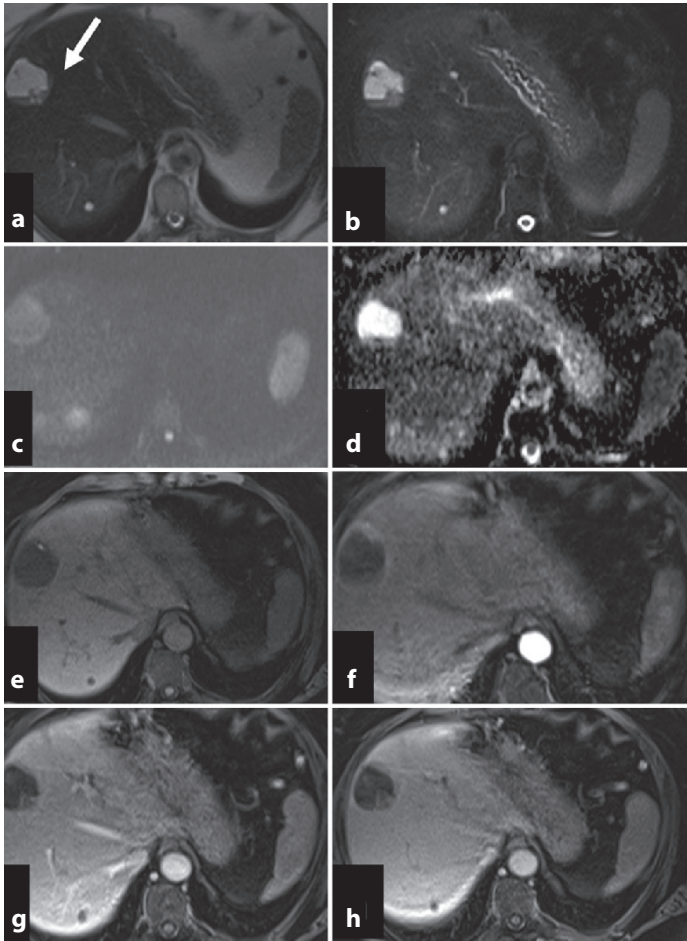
MR imaging of liver metastasis from a malignant non-functioning P-NET in a 70-year-old woman. A rounded well-defined hepatic lesion in segment VIII (30 mm) appears hyperintense on axial T2-weighted MR imaging (a) and axial T2-weighted fat-suppressed imaging (b) due to the internal cystic component. On the diffusion-weighted image with high b value (c) and the ADC map (d) the tumor shows hypercellularity at the outer border with appreciable restriction of the movement of the water molecules. On dynamic contrast-enhanced fat-saturated T1-weighted images, acquired before contrast media administration (e), during the arterial (f) portal (g) and equilibrium (h) phases, the tumor appears hypointense to the surrounding parenchyma, showing a hypervascular ring enhancement
